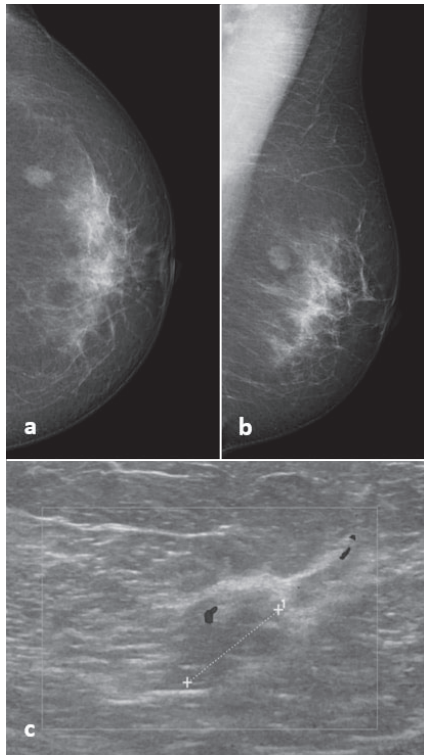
53-year-old woman with a 1.3-cm mass on a, b mammography and c ultrasound, initially classified as BI-RADS 4. Mammography-guided core needle biopsy revealed benign papilloma without atypia. Diagnosis was confirmed after surgical excision.
